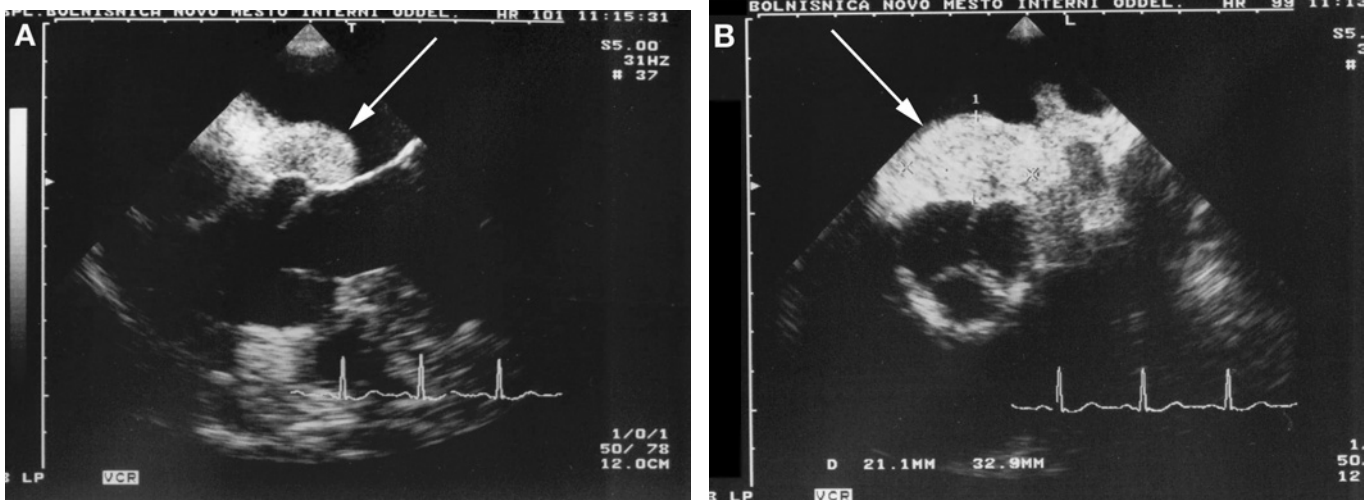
Transesophageal longitudinal view (A) and transversal view (B) show the tumor (arrow) located in the left atrium adjacent to the mitral valve annulus, lying adjoining the posterior aortic wall.
